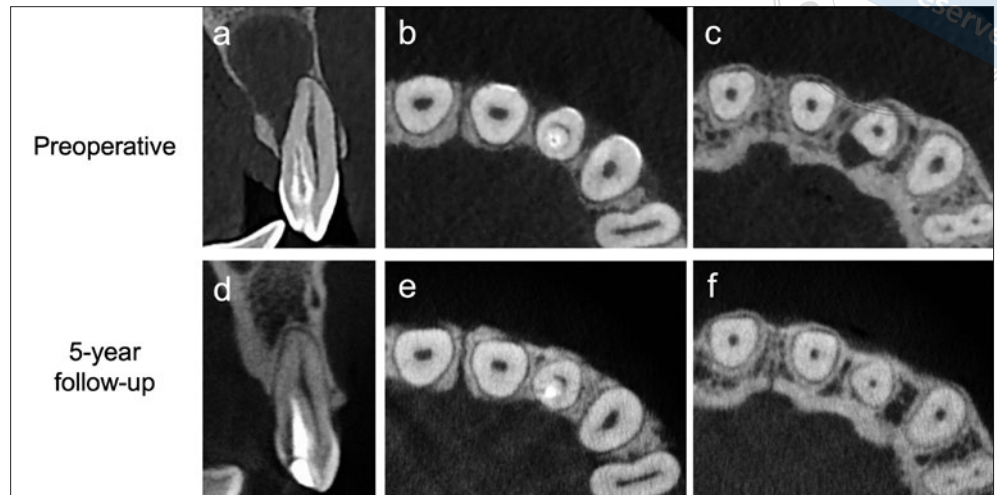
Preoperative CBCT images of the maxillary left lateral incisor (a to c). The 5-year follow-up CBCT images show complete healing of the radiolucency (d to f).
